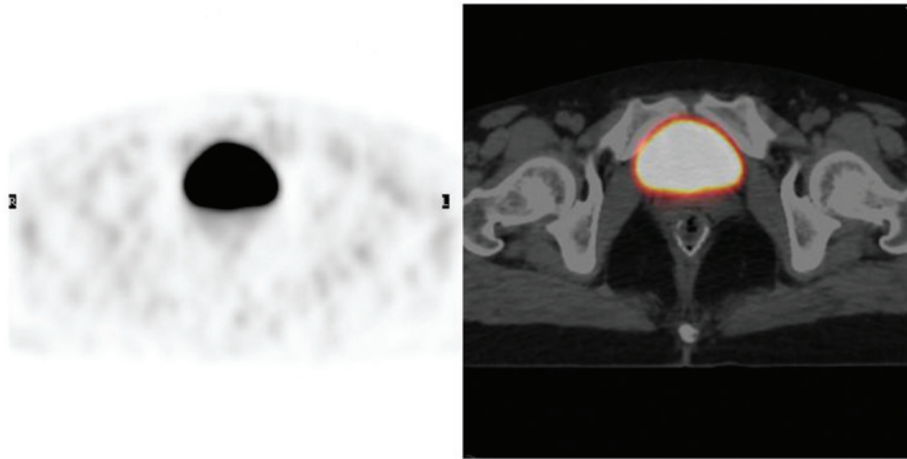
Transaxial PET (left), and fused PET/computed tomography (right) slices demonstrating no ^{18}F -fluorodeoxyglucose uptake in the rectum following 3 cycles of post-operative chemotherapy. PET, positron emission tomography.
